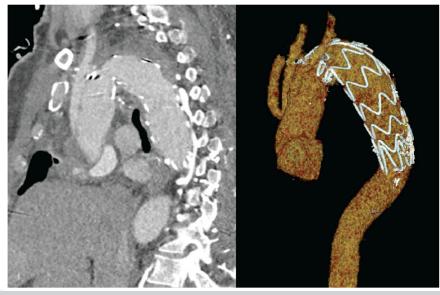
Postoperative computed tomography angiogram of the chest.
